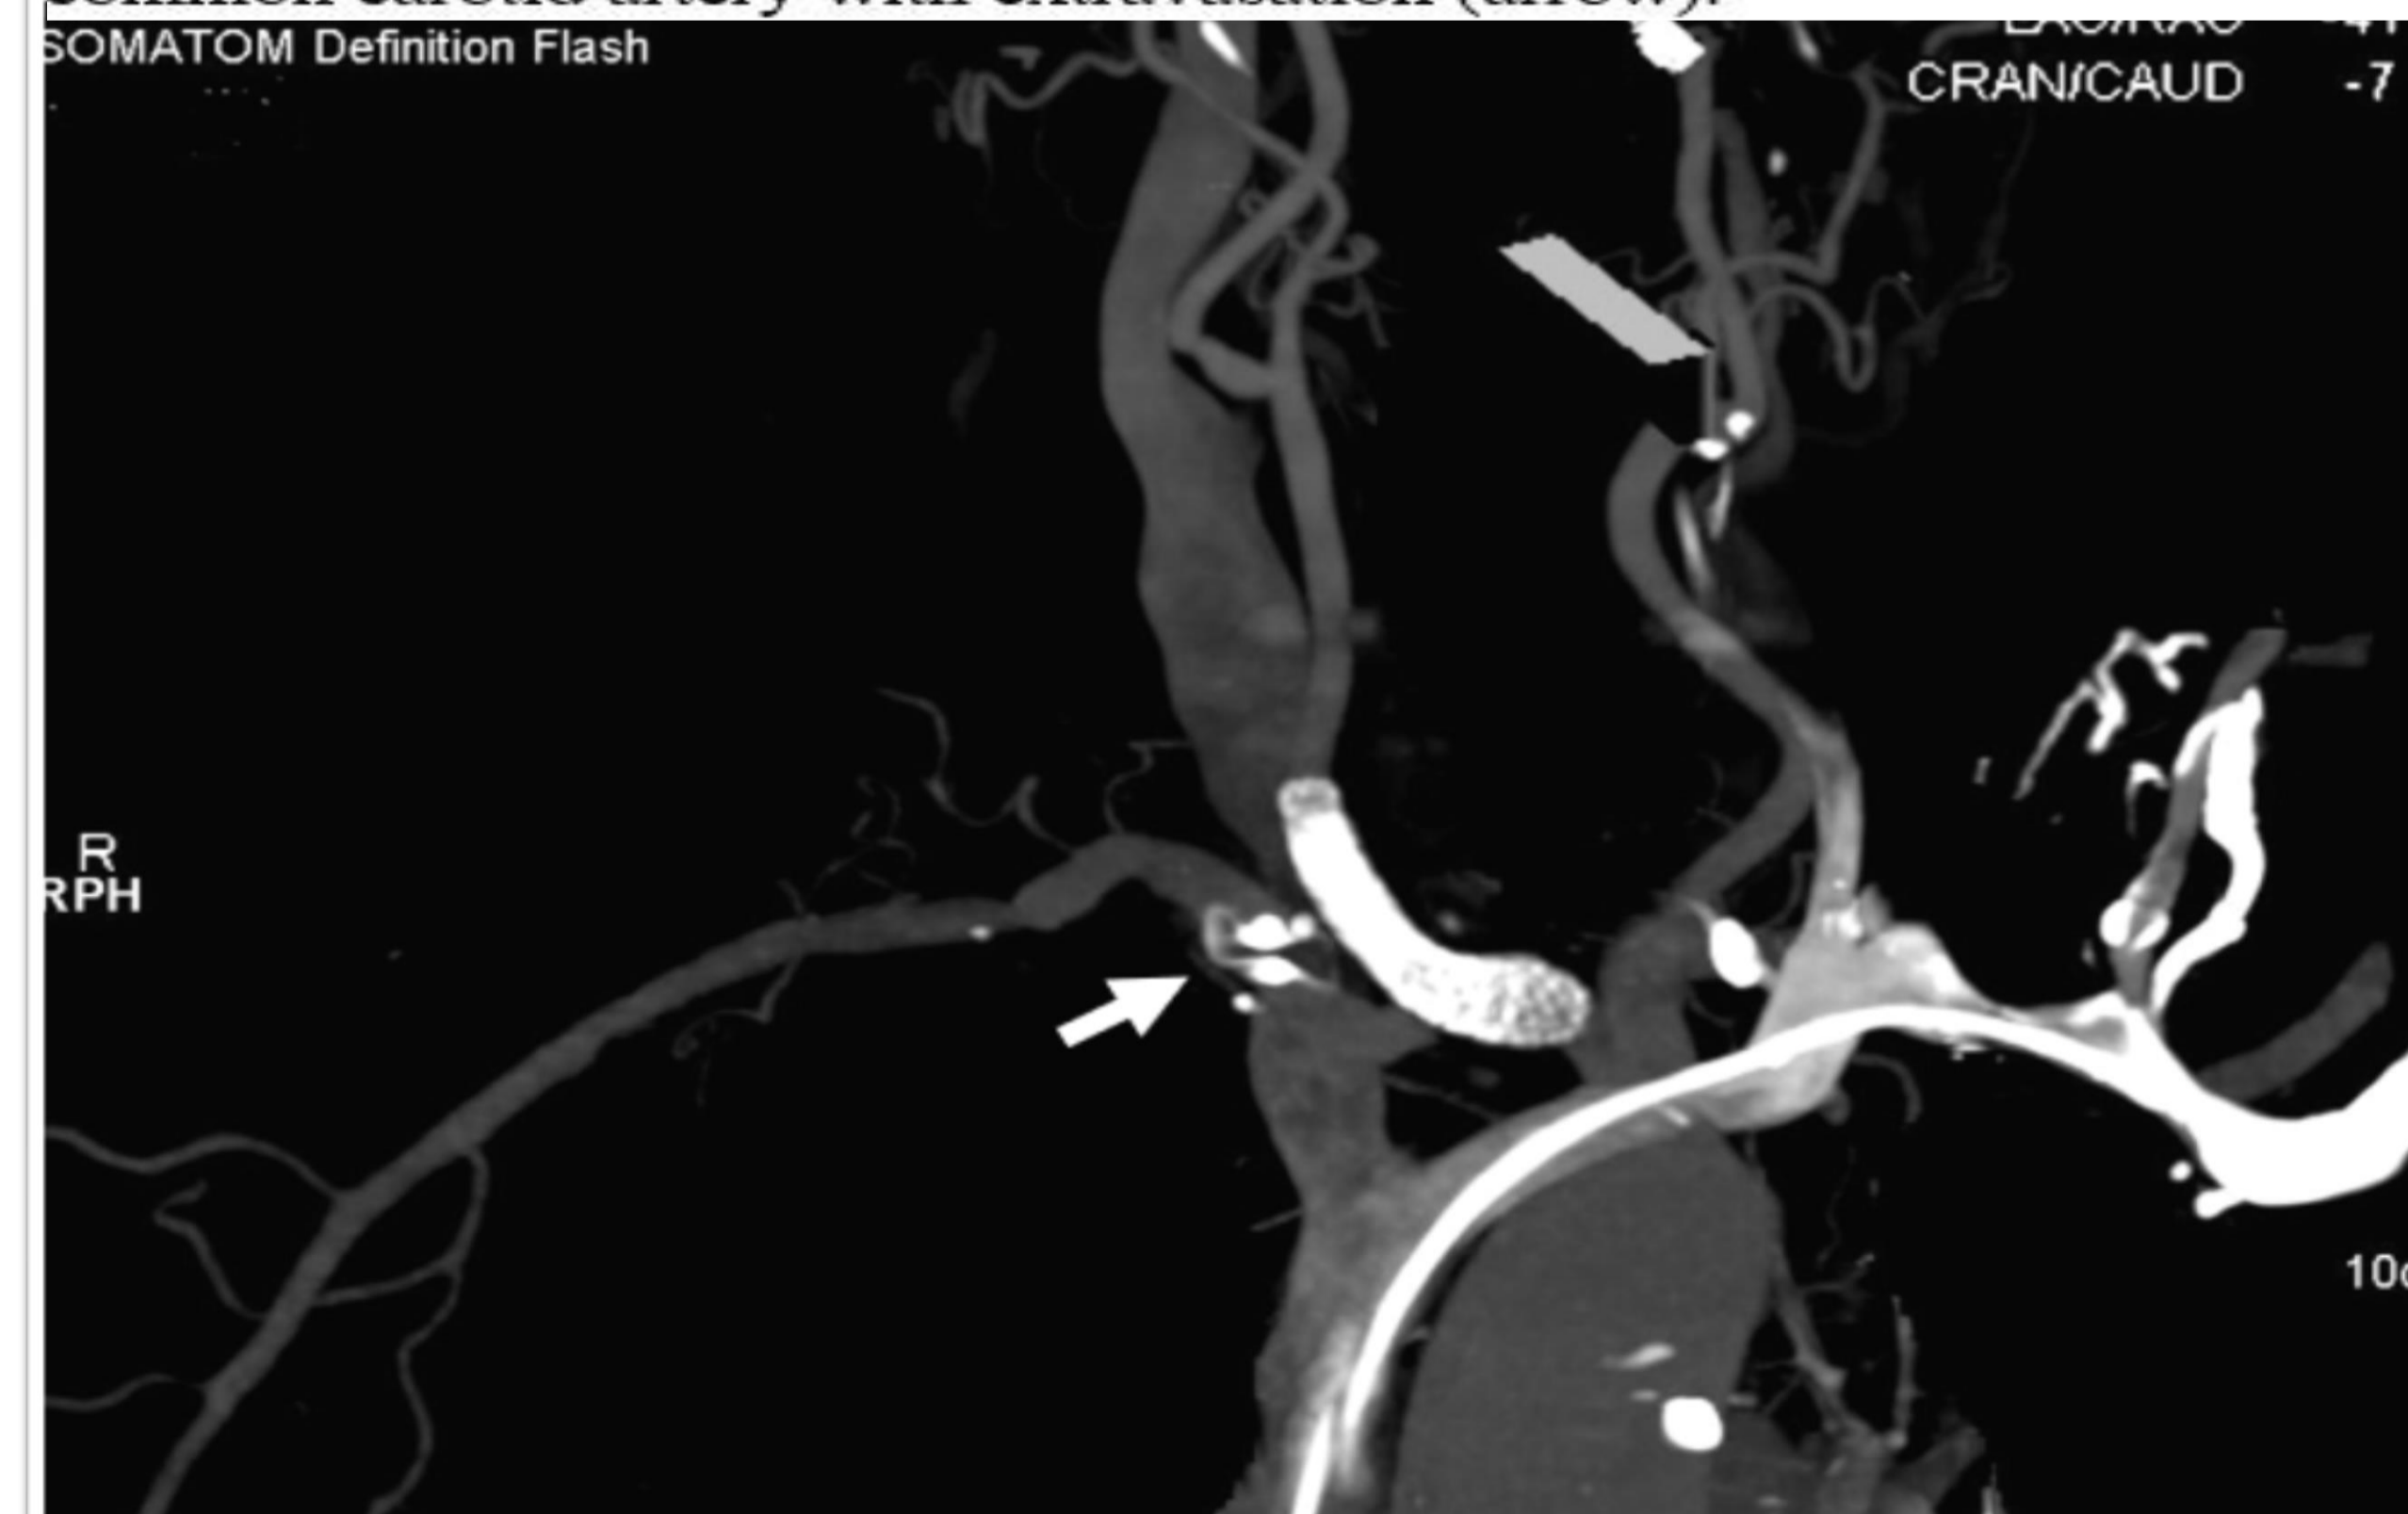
Coronal reformat CT angiogram. Performed 72-hr post-procedure demonstrating patency of the Viabahn VBX stent and the AMPLATZER plug (arrow) within the right SCA. A left subclavian central venous catheter can also be visualised.
